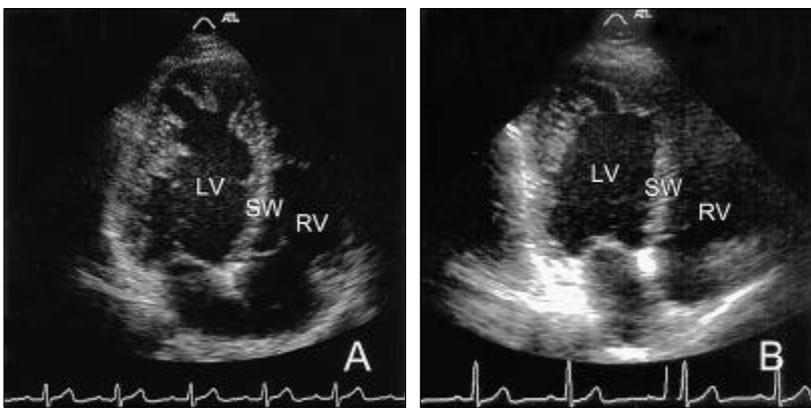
Transthoracic echocardiograms (TTE) of the affected other family members. (A) Apical 3-chamber view of Patient II-1 and (B) apical 4-chamber view of Patient II-3 show the peculiar appearance of INVM, characterized by prominent trabeculations and deep recesses. LV, left ventricle; RV, right ventricle; SW, septum wall.
